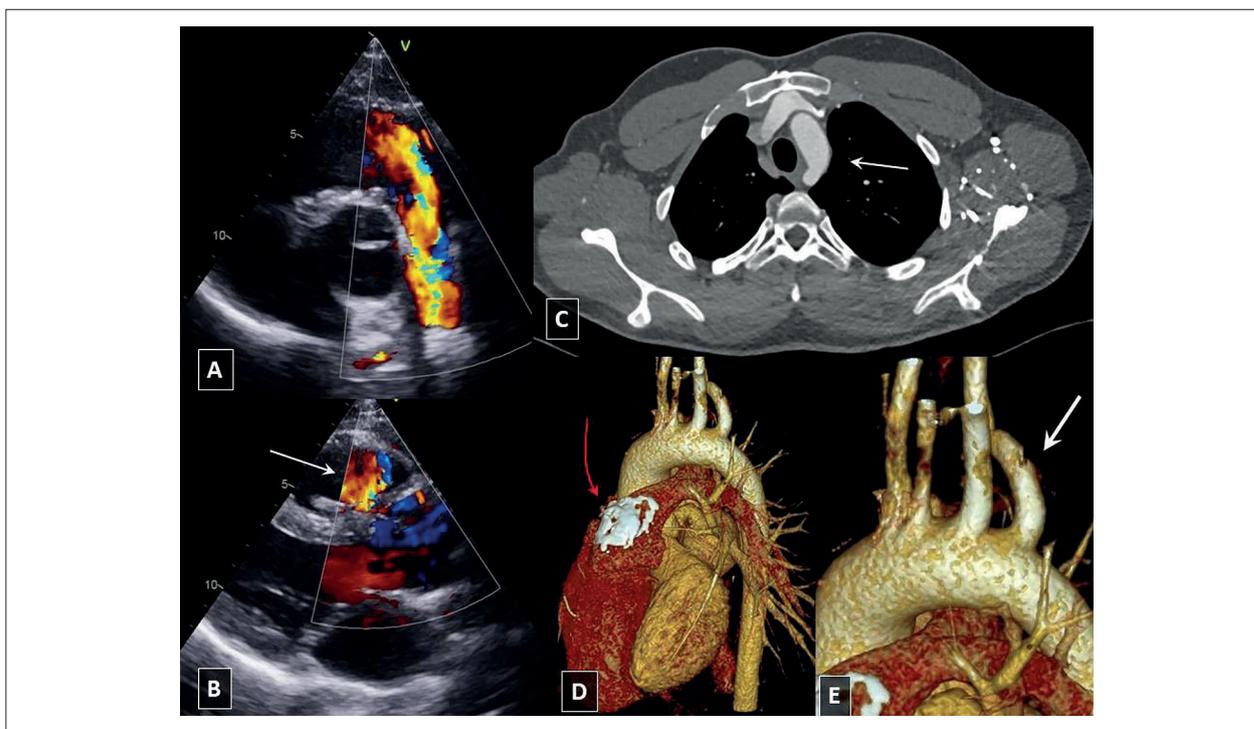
Patient 2 A) Transthoracic echocardiography, parasternal short axis view. Significant regurgitation across the pulmonary homograft; B) Transthoracic echocardiography, parasternal long axis view. Jet of the significant pulmonary regurgitation visible in the right ventricle outflow tract (white arrow); C) Cardiac computed tomography, axial plane. White arrow indicates left-sided aortic arch; D) Cardiac computed tomography. Visible calcifications of the pulmonary homograft at the level of the pulmonary valve (red arrow). E) Magnification of panel “D” with a focus on the right aberrant subclavian artery (white arrow) branching-off from the left-sided aortic arch.
